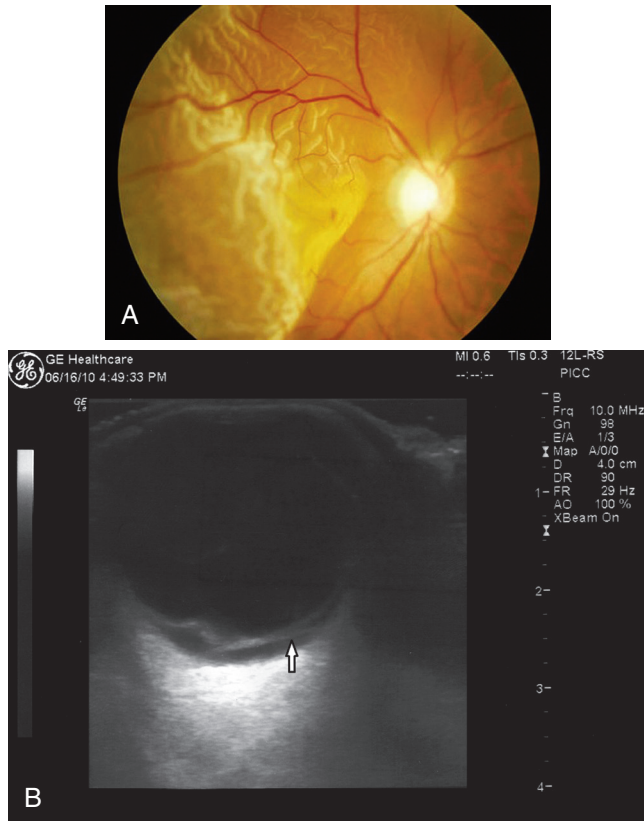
A, Retinal detachment. Note large portion of retina pulling forward. B, Bedside emergency department (ED) ultrasound showing retinal detachment (white arrow). (A, Courtesy www.tedmontgomery.com. B, Courtesy Nicholas Connors, MD, and Sophia Lin, MD, New York Presbyterian-Weill Cornell Medical Center.)
